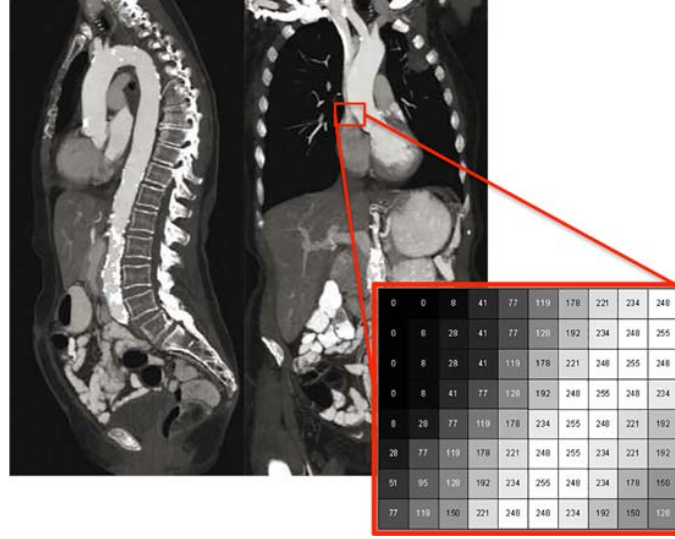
Computed tomography angiography (CTA) of the chest and abdomen. The image is composed by a large serial 3D array of data values, defined as $I(\mathbf{x})$, where $\mathbf{x} \in \mathbb{R}^3$ are the spatial (plane) coordinates, and the amplitude of I at any coordinates \mathbf{x} is called the intensity or grey level of the image at that point.
